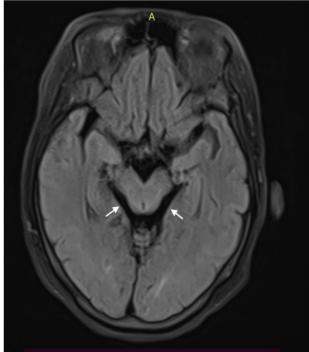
MRI brain: 1a. T1 axial image showing signal change in bilateral cerebral peduncle, 1b. FLAIR axial showing signal change in mid brain.
